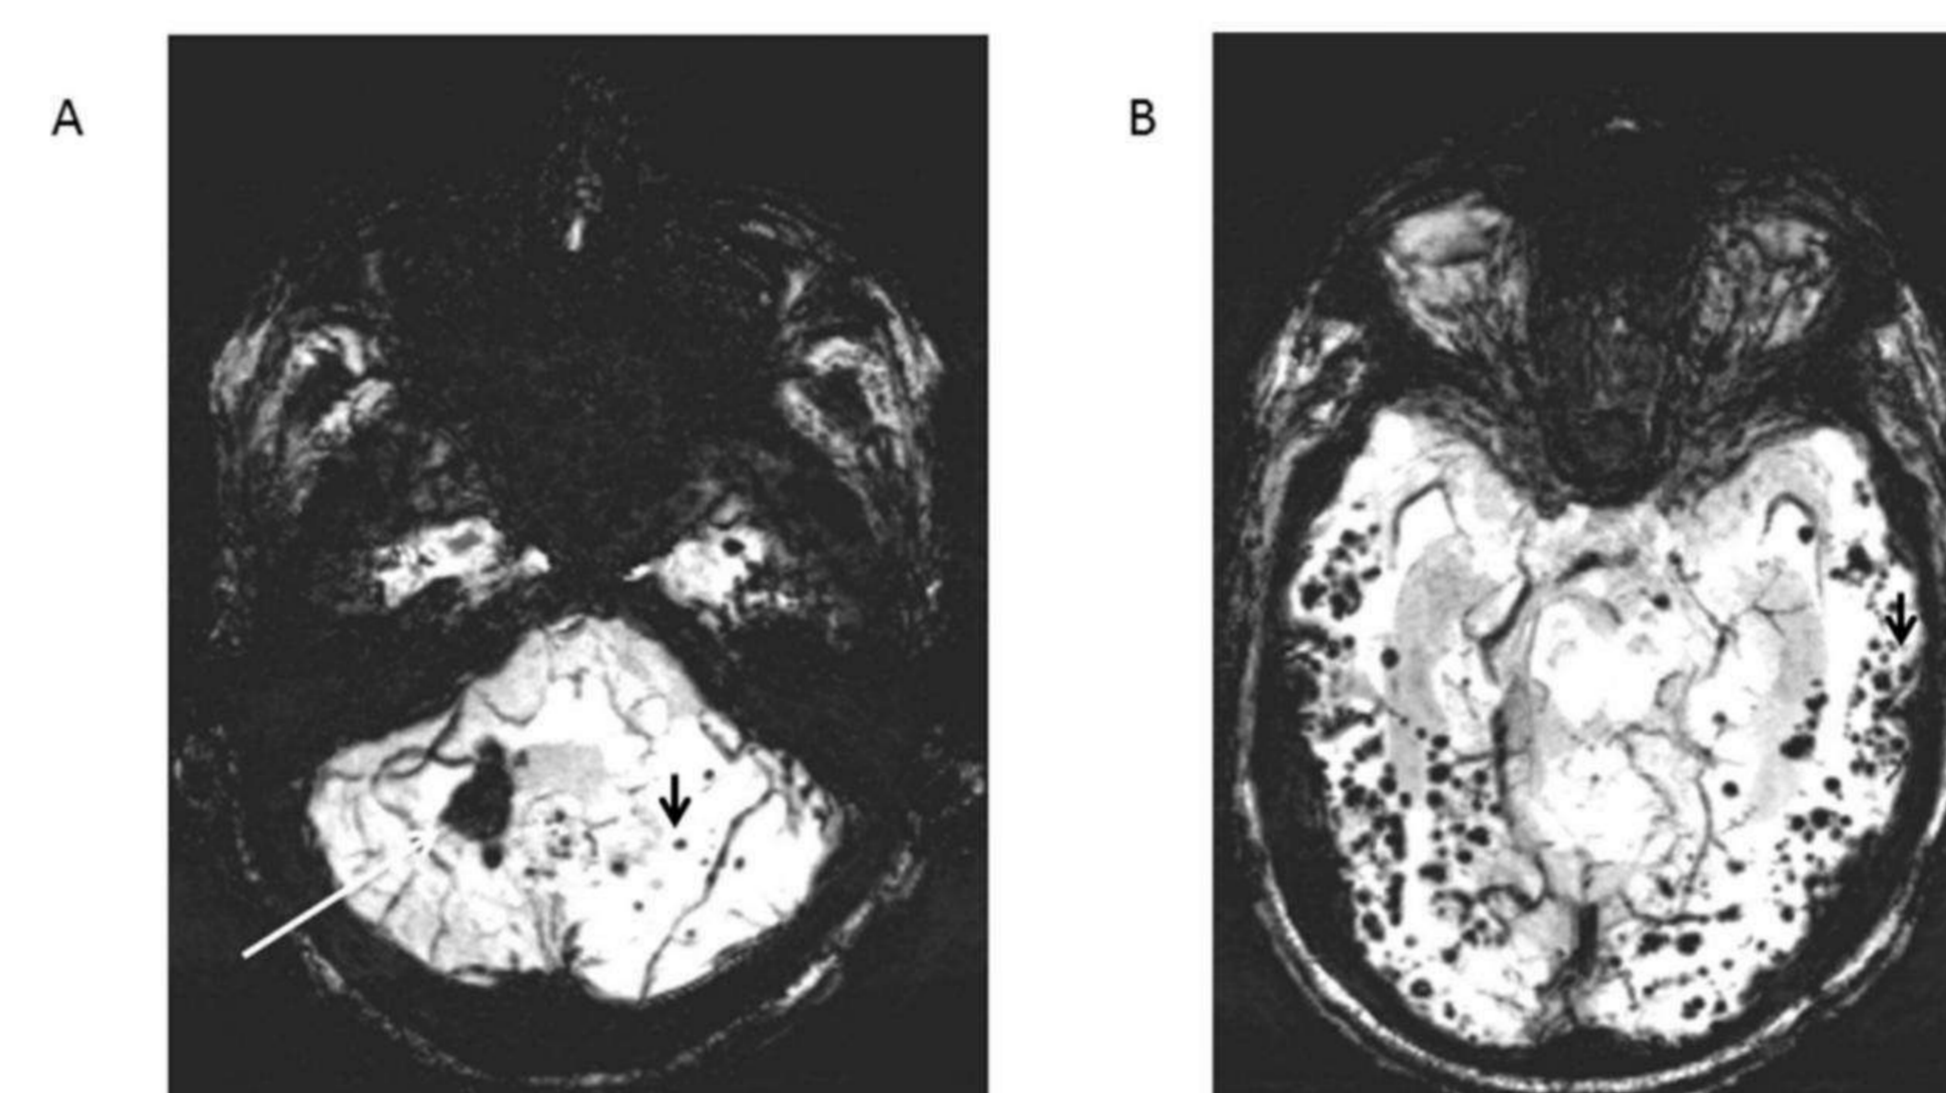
Typical SWI MRI images from a patient with hypo-intense cerebellar macro (A. long white arrow) and micro-hemorrhages (short black arrow) as well as cortical lobar micro-hemorrhages (B, short black arrow) typical for cerebral amyloid angiopathy.
